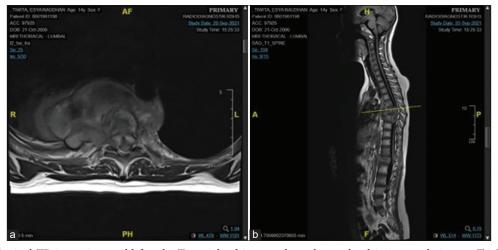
MRI of spinal TB in a 14-year-old female. T1-weighted images showed extradural isointense lesions at T6-T8 and L1, which intensify inhomogeneously with contrast administration. Note also that there is bone destruction. T2-weighted images showed extradural isohyperintense lesion at T6-T8 and L1 with bone destruction, canal stenosis at T6-T8, and L1, and kyphotic angle 16°. (a) Axial view; (b) Sagital view.
